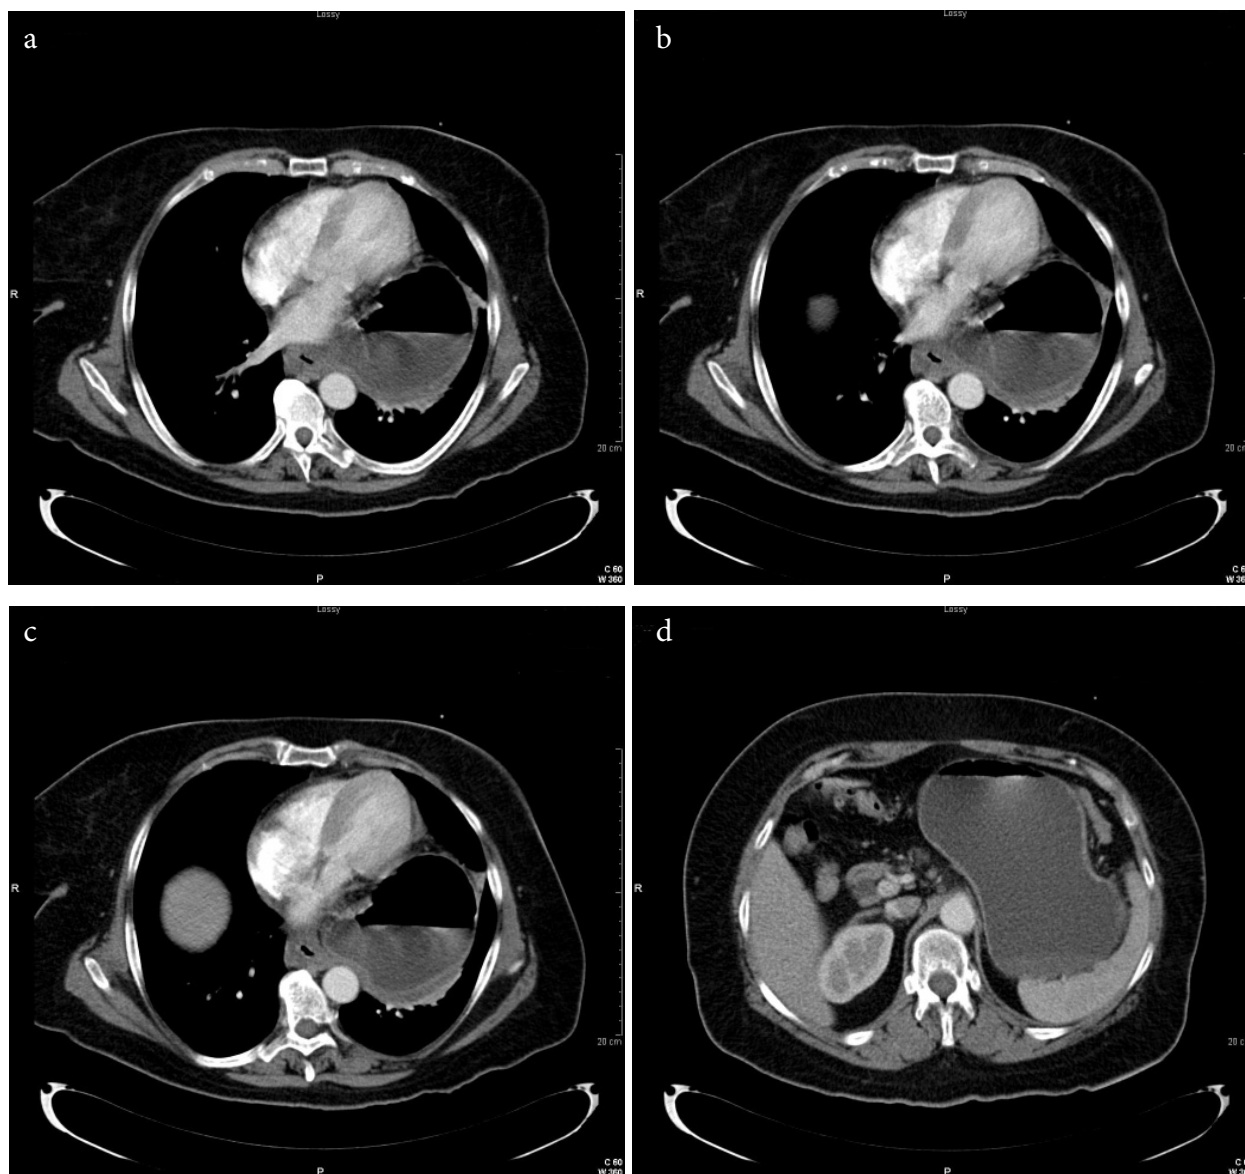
a) Horizontal section of the Computed tomography (CT) scan of the chest showing a large hiatal hernia b) Computed tomography (CT) scans of the chest showing a large hiatal hernia, a horizontal view. c) Computed tomography (CT) scans of the chest and abdomen showing a large hiatal hernia (Horizontal view). d) Horizontal Computed tomography (CT) scan of the abdominal area showing a hiatal hernia.
